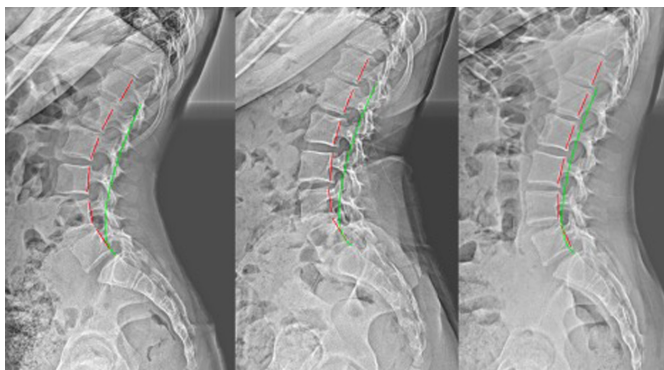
Lateral lumbar radiographs. Left: Initial showing lumbar hyperlordosis, increased sacral base angle and forward translation of the thorax; Middle: First follow-up; Right: Second follow-up.
